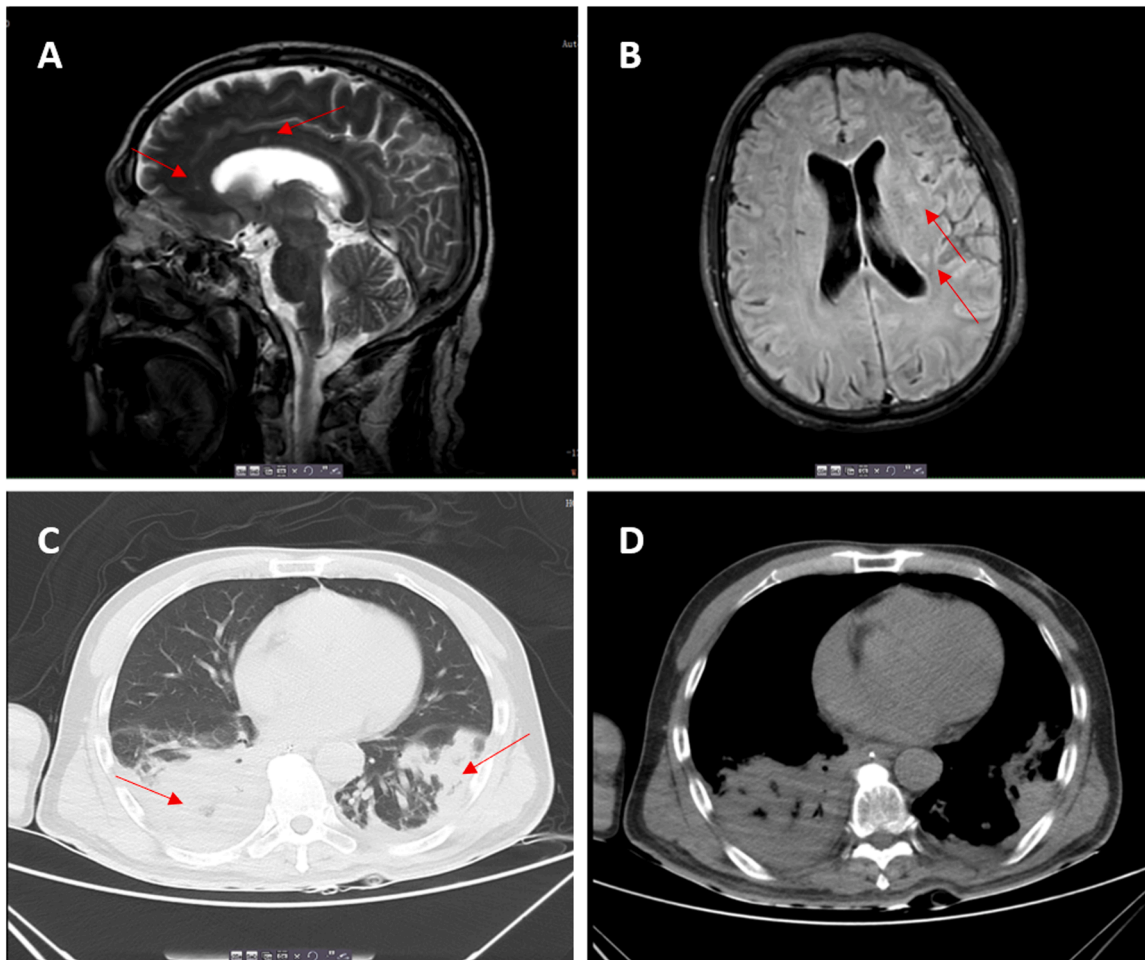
Cranial MRI revealed the presence of numerous abnormal signals in various regions including the bilateral temporal lobes, hippocampus, sylvian cistern, bilateral cerebellum, and fourth ventricle, indicating a potential case of encephalitis (A and B). Additionally, a chest CT scan exhibited the presence of multiple lung inflammations, pleural adhesions, and pleural effusion (C and D).
